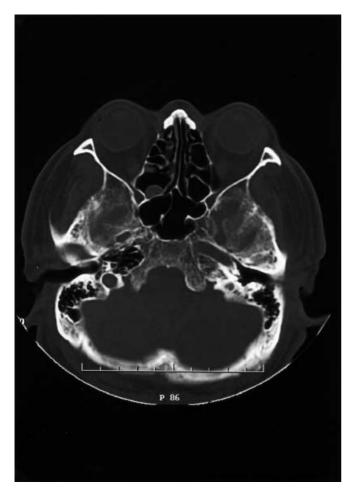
Bone image of skull base. Computed tomography of the skull base reveals absence of the right carotid canal, suggestive of right ICA agenesis
